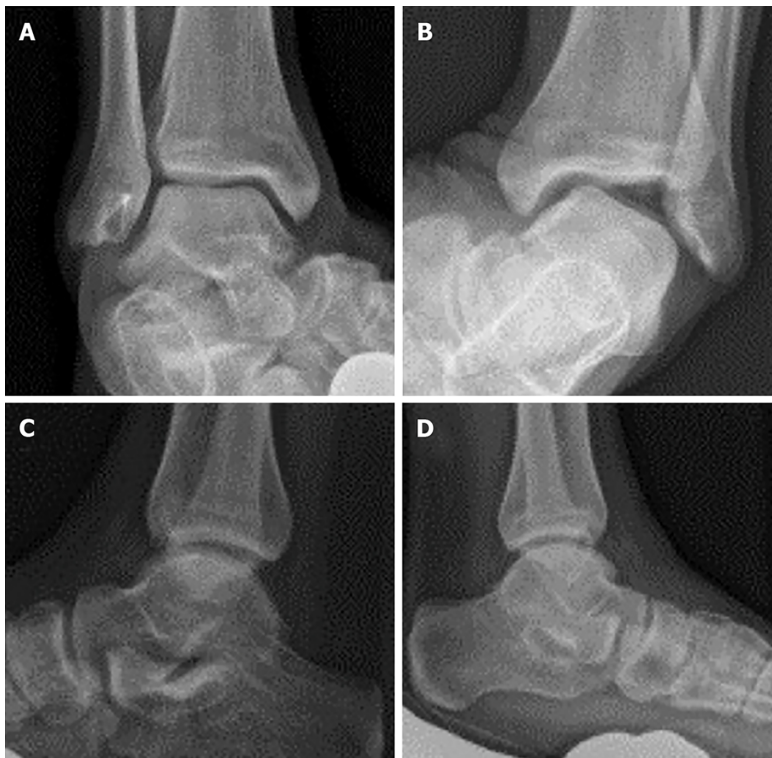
Stress radiographs. A: An example of a stable ankle which has previously undergone a modified Broström procedure is depicted; B: The contralateral ankle demonstrating instability on the talar tilt examination is depicted; C and D: The corresponding anterior drawer stress radiographs.
